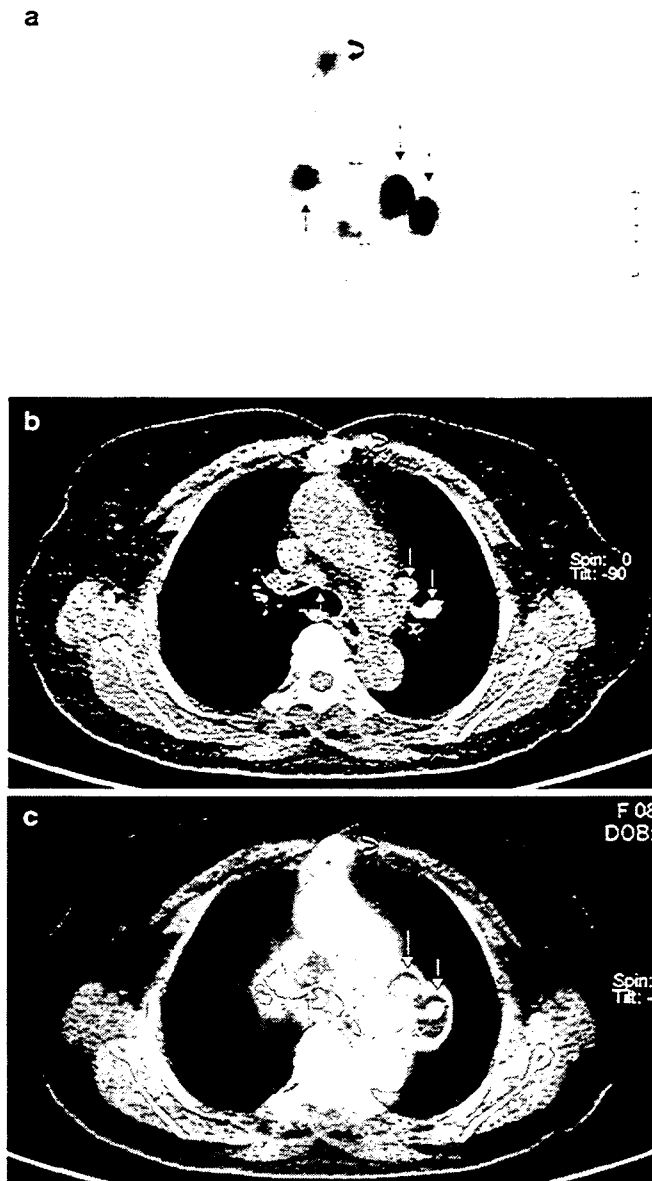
An 82-year-old woman with initial FIGO stage III c with mediastinal and hilar lymph node metastases. Axial PET (a), CT (b), and PET/CT (c) showing mediastinal and hilar lymph node metastases (arrows)
